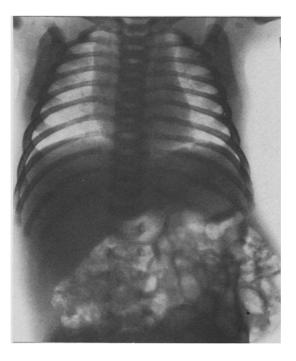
X-ray picture at the age of 4 wk.
